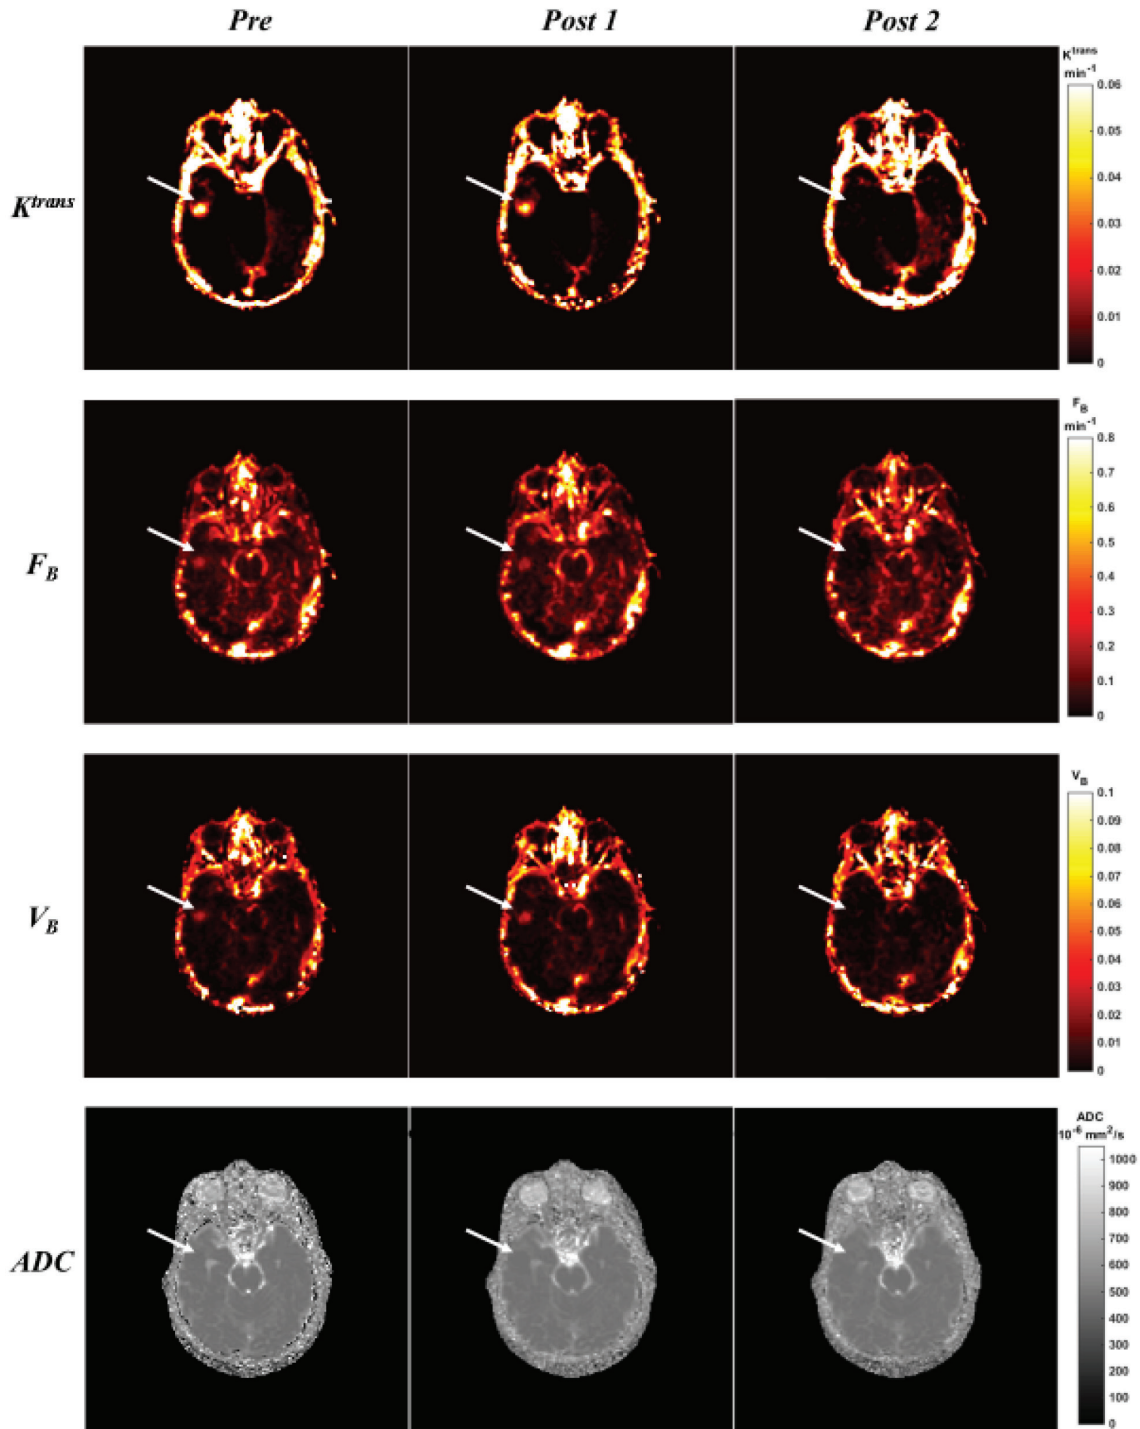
shows the comparison of functional MR parametric maps from a selected patient (No. 11 in Table 1) on all three MR exam days. The DCE-MRI biomarker maps ( $K^{trans}$ ,  $F_B$  and  $V_B$ ) demonstrated elevated intensity distribution around PTV region in the pre-treatment scan. This observation confirmed microvessel abnormality of the PTV region. In the 1<sup>st</sup> post-treatment scan, these 3 maps showed minor changes; in contrast, the decrease of intensity in all three maps could be easily appreciated in 2<sup>nd</sup> post-treatment scan, suggesting a suppression of microvessel activity. The ADC distribution from DW-MRI did not demonstrate noticeable differences in Figure 2.
